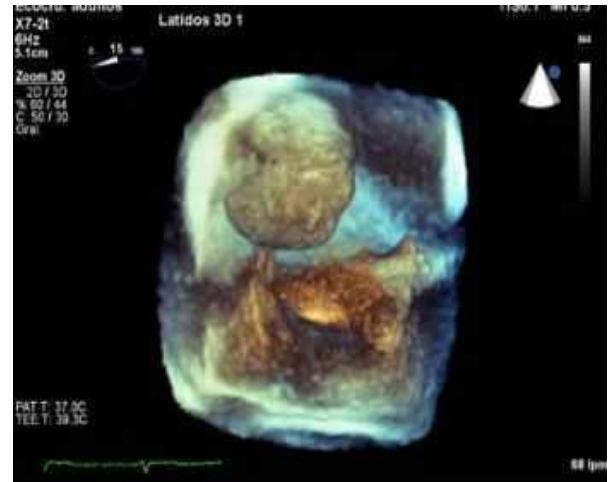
Transesophageal echocardiogram in 2D and 3D mode respectively, showing a well-defined left atrial tumor of 14 by 17 mm.
